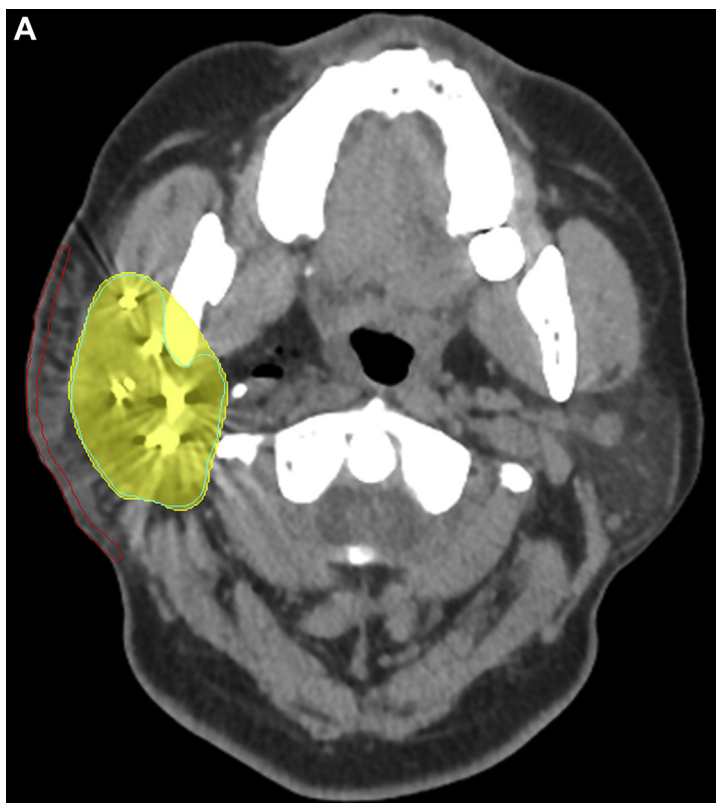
A, A computed tomography image for postoperative quality verification shows that the subcutaneous layer is filled with hyaluronic acid and the skin is away from the target area. (Fig 1 continued on next page.)
